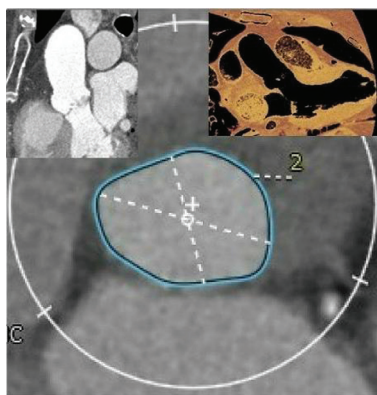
AVAi calculated with continuity equation and ventricular outflow tract area evaluated by computed tomography
